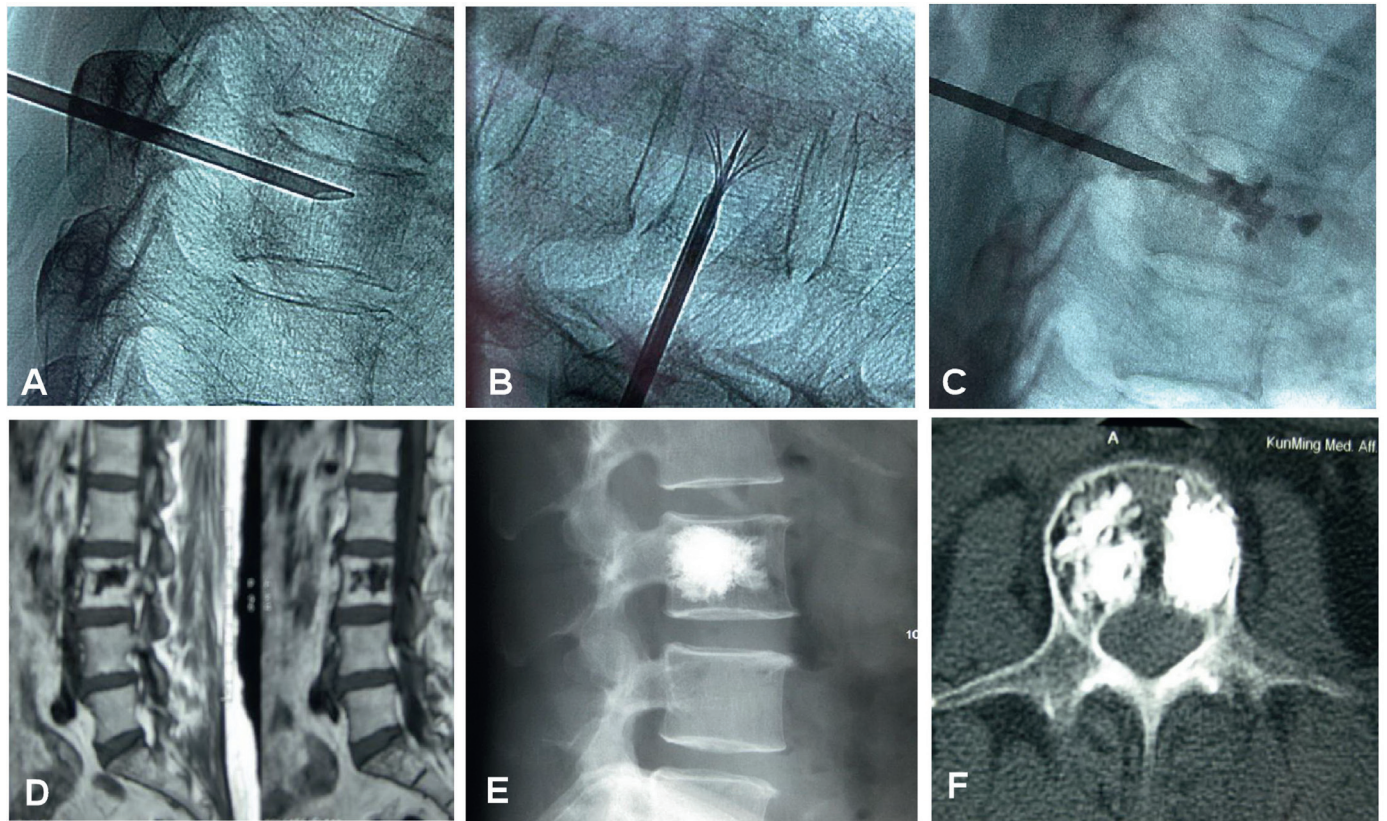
The combined radiofrequency ablation and percutaneous vertebroplasty with cement injection was performed in patients with spinal tumors. (A) An exterior trocar was inserted into the center of the vertebral body. (B) The clustered electrode with 13 hooks were inserted through the trocar into the vertebral body for ablation. (C) After ablation, the electrode was withdrawn and cement was injected. (D) Magnetic resonance imaging showed an irregular zone of osteolysis in the third lumbar vertebral body. (E, F) After ablation and cement injection, the cement was distributed well in the osteolytic area.
